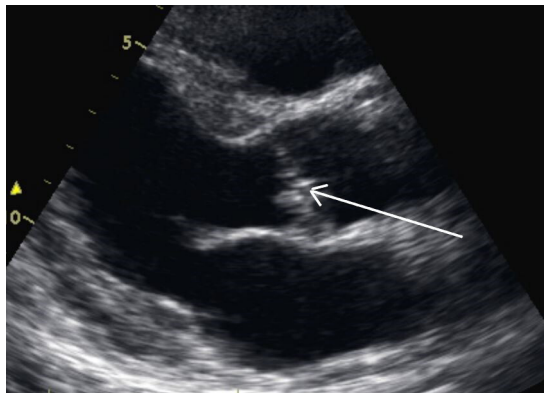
Transthoracic echocardiogram showing a small vegetation on aortic valve non-coronary cusp.
